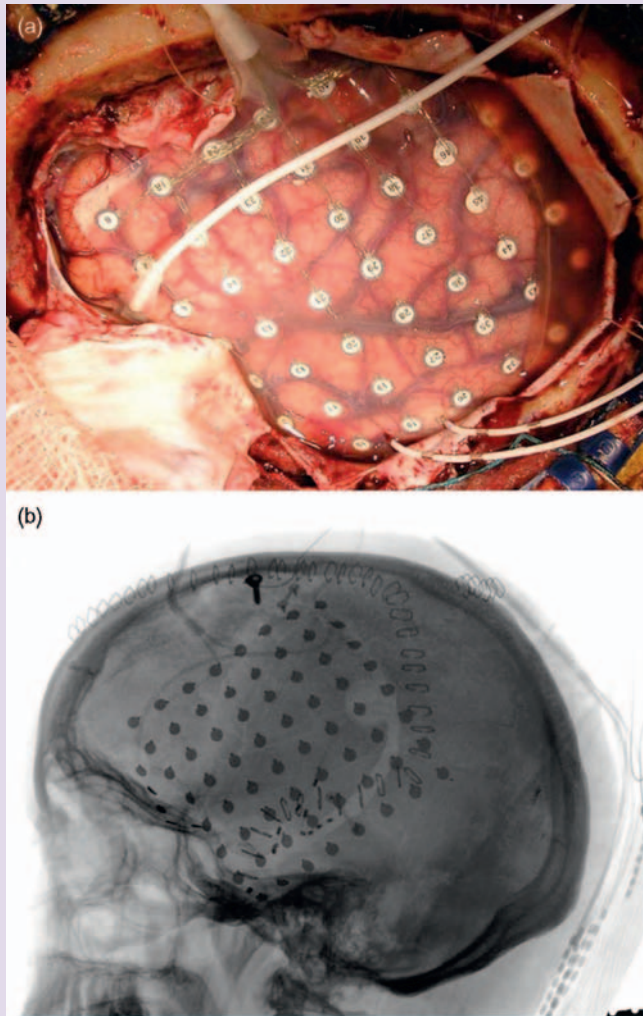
(a) A surgically exposed cortex with an 8×8 electrode grid placed directly on the surface. The electrodes (white circles) are mounted on a transparent plastic square that is overlaid on the left hemisphere. Notice that the grid covers part of the temporal lobe, a common source of seizure activity. It also samples the receptive language region of the left hemisphere (Wernicke’s area), as well as Broca’s area (the left inferior frontal gyrus), which controls language production. The left hemisphere is dominant for language in most people, and the electrodes are therefore placed over the most critical locations. (b) An X-ray radiograph of the same patient, superimposed on a structural MRI of the lateral brain. Source: Dalal *et al.* (2008).
